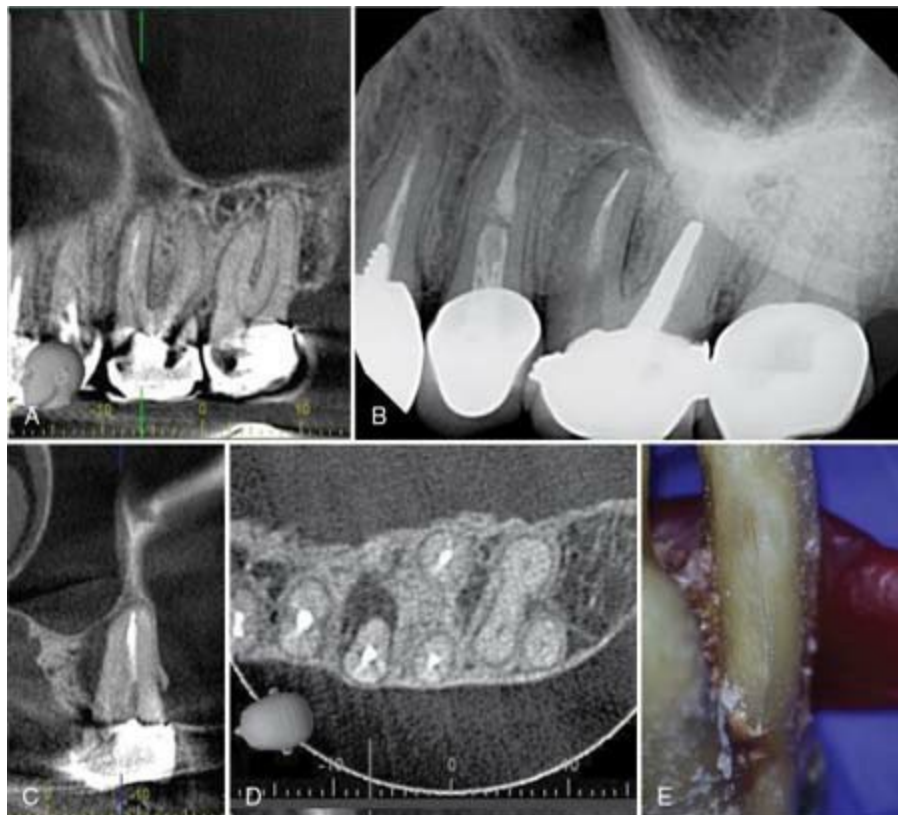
A to E, Vertical root fractures observed with periapical radiograph, cone-beam computed tomography and clinically after extraction.
